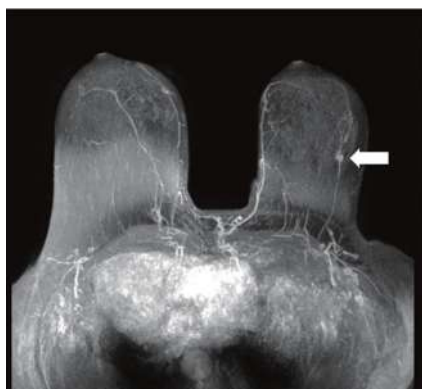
Abbreviated MRI Protocol Using Maximum Intensity Projection (MIP)
